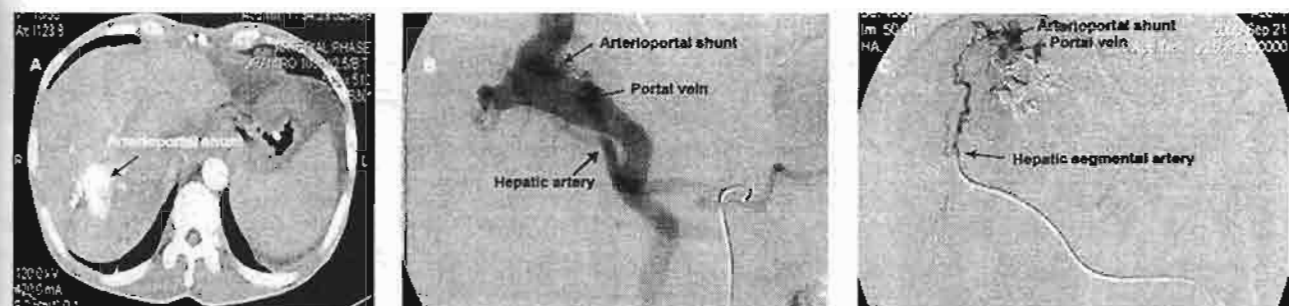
Imaging of the hepatic arteriovenous malformation in the proband. (A) Computed tomographic scan of the upper abdomen showing hepatic arterioportal shunt. (B, C) Angiogram of the hepatic arteriovenous malformation showing a large high flow arterioportal shunt from hepatic arteries to portal vein with marked enlargement of portal vein. (Please note that a colour version of this figure is available as supplementary data at <http://www.jjco.oxfordjournals.org>)
